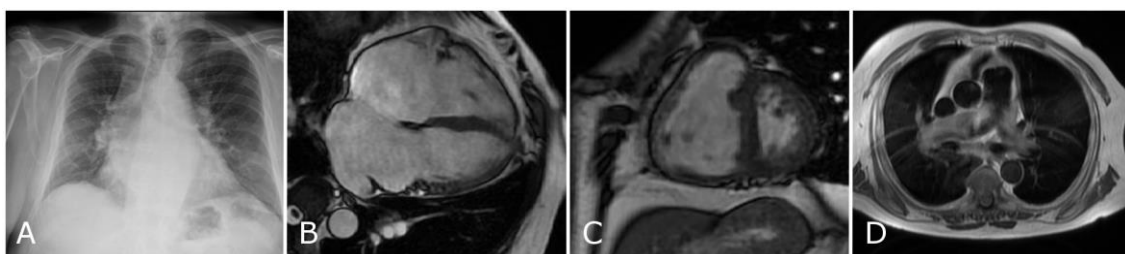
Typical features of pulmonary hypertension due to left heart disease. A chest radiograph (A) showing moderate cardiomegaly and upper lobe venous distension. Subsequent magnetic resonance imaging (MRI) shows bi-atrial dilatation (B), flattening of the interventricular septum (C) and slow flow black blood artefact (D). The flattening of the interventricular septum suggests that there is a pre-capillary component to the pulmonary hypertension.
